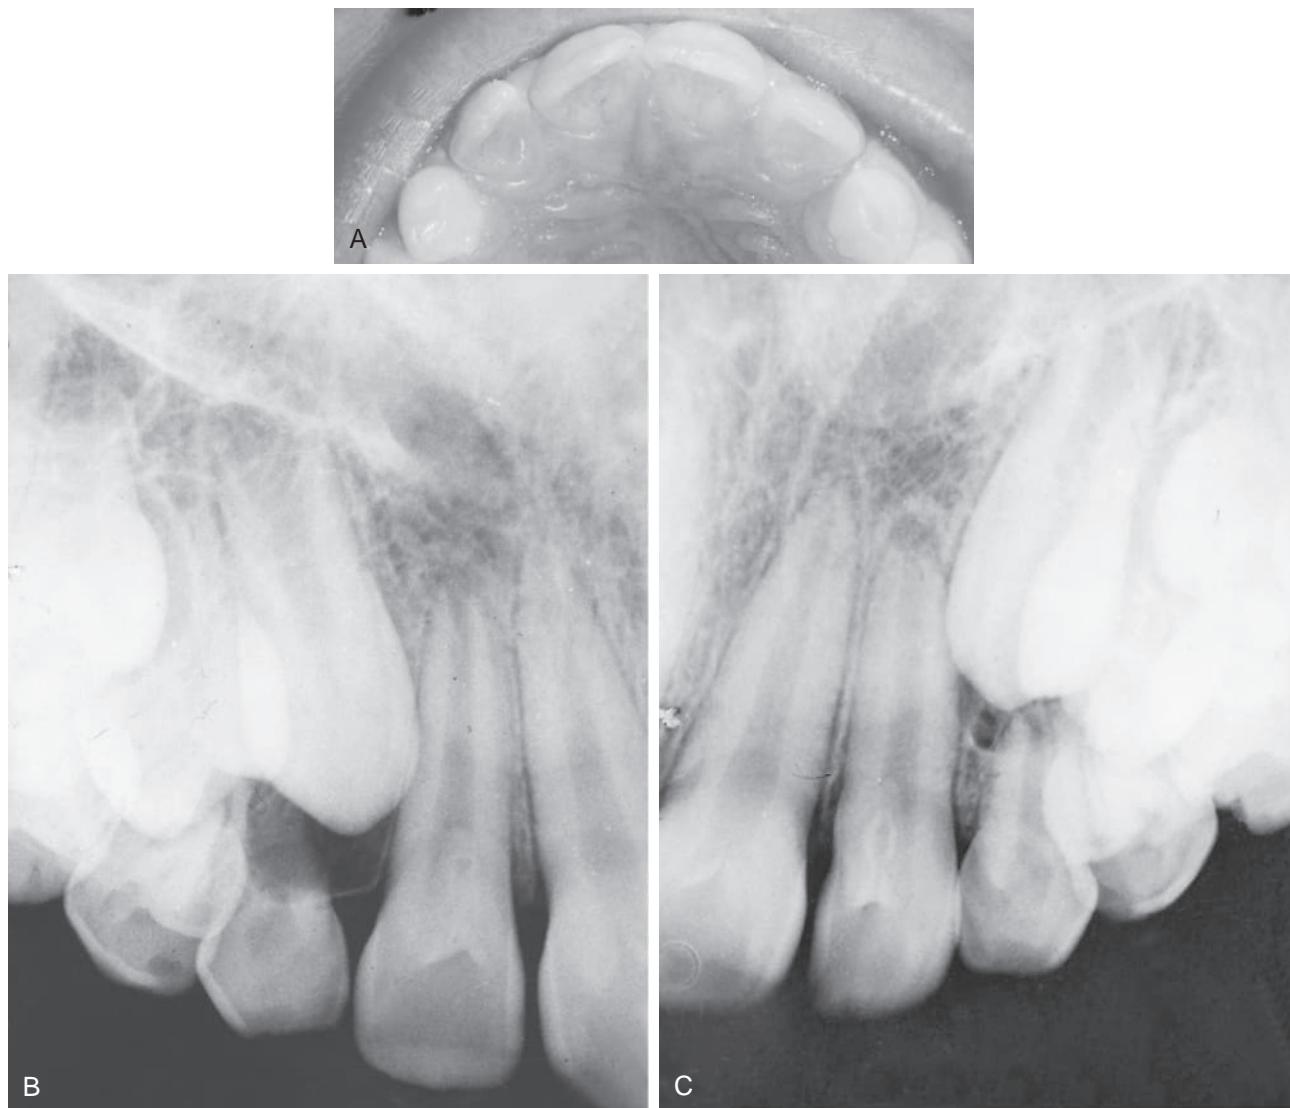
(A) Small, “nonsticky” pits on the lingual surfaces of the maxillary lateral incisors are the only clues to the *dens in dente* condition of the teeth revealed radiographically in (B) and (C).
